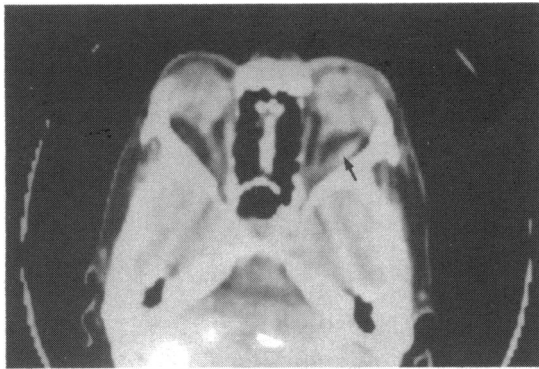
CT scan of case 2 demonstrating a thickened and enlarged right lateral rectus muscle (arrow). Note that muscle enlargement appears less by this technique.
